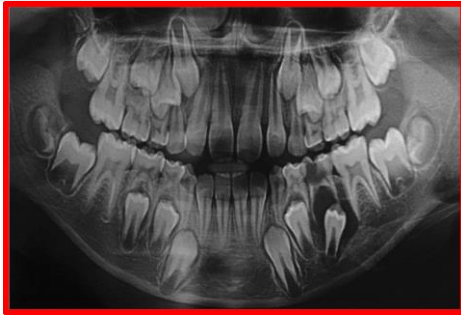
Panoramic radiograph shows the grossly destroyed 75. A well-defined unilocular radiolucency with sclerotic borders can be seen in the periapical region of 75.
